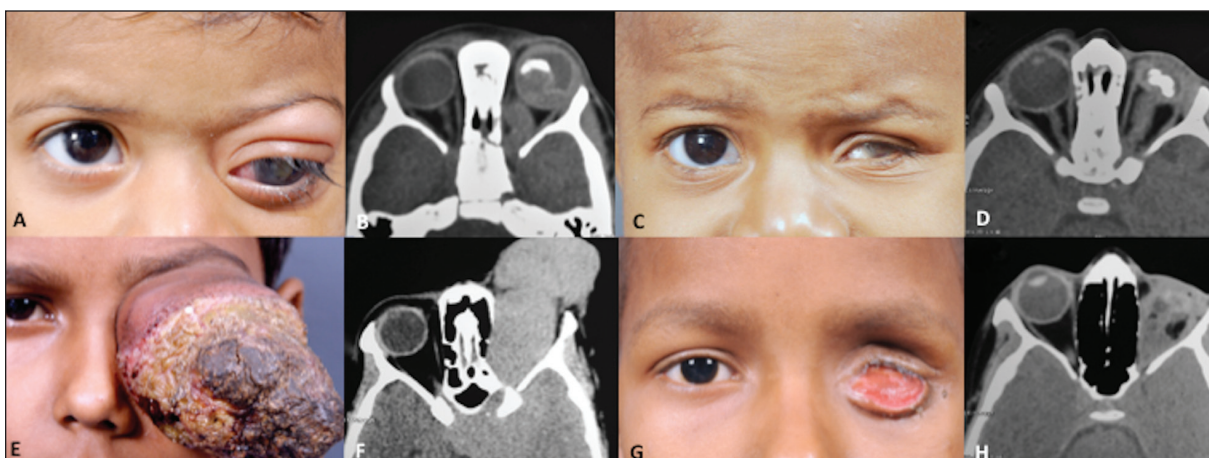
Patient with optic nerve extension of retinoblastoma. (A) A 12-month-old girl presented with leukocoria and proptosis. (B) On computed tomography (CT) of the orbit, there was retinoblastoma with optic nerve extension. (C) The globe became phthisical after 9 cycles of systemic chemotherapy. (D) CT orbit showed decrease in optic nerve thickening. The child underwent enucleation, external beam radiotherapy, and 3 more cycles of systemic chemotherapy and is doing well at 36 months of follow-up. (E) A 9-year-old boy with massive extraocular extension of retinoblastoma. (F) On CT of the orbit and brain, there was retinoblastoma with massive extrascleral extension, optic nerve extension, and intracranial extension. (G) The child showed dramatic response to 6 cycles of systemic chemotherapy with phthisis bulbi. (H) CT of the orbit and brain revealed minimal residual component of orbital lesion. The intracranial portion of the tumor had regressed. The child underwent orbital exenteration but died of the disease before completion of adjuvant systemic chemotherapy and radiotherapy.
